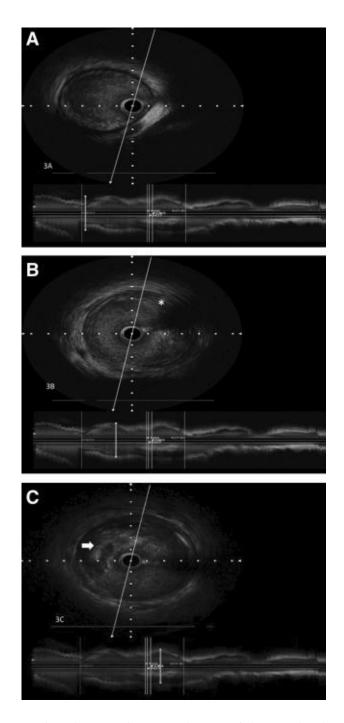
Figure A-3. (A) Intravascular ultrasound (IVUS) image of the proximal LAD. (B) IVUS image showing the eccentric plaque with 25% plaque burden seen proximal to the thrombus burden, which is suspected to be the culprit lesion. Asterix * in the image indicates the eccentric plaque.
